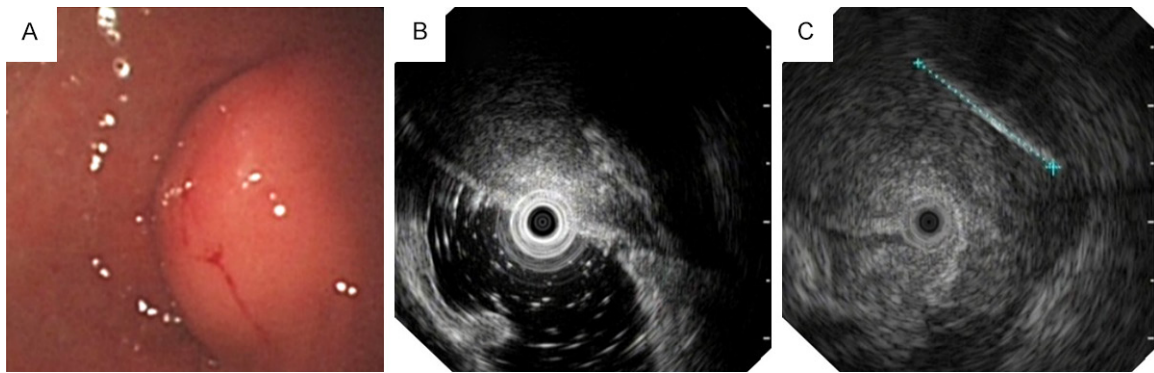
A submucosal mass on the posterior wall of the gastric antrum was observed by gastroscopy (A). Endoscopic ultrasonography at 20 MHz showed that the lesion originated from the muscularis propria layer (B). Endoscopic ultrasonography at 12 MHz showed that the lesion originated from the muscularis propria layer and had a diameter of about 20 mm (C).
